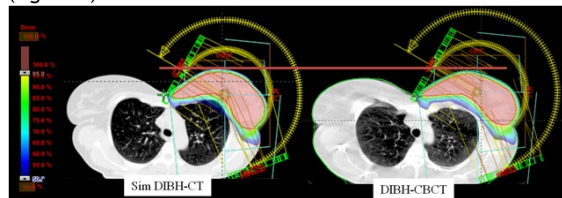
Dose recalculation on a DIBH-CBCT. Similar results were obtained in all cases. Conclusion DIBH-CBCT was shown to be feasible with adequate image quality, making possible to evaluate the efficacy of VMAT skin flash tool approach also in DIBH condition. Considering the relative short image acquisition time required, a protocol for DIBH breast SIB treatments in 15 fractions with DIBH-CBCT daily position is starting in our department.
